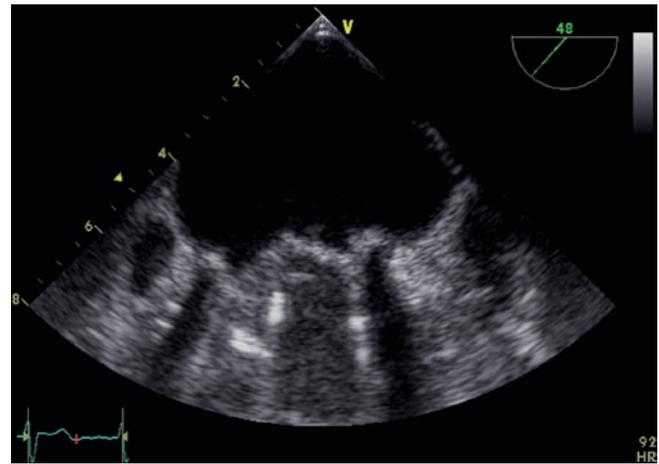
Trans-oesophageal echocardiographic visualization of a normofunctioning bileaflet tilting-disc prosthesis in the mitral position. The metallic leaflet are very well visualized in systole, in the closing position. During systole there is an intense shadowing on the left ventricular side
